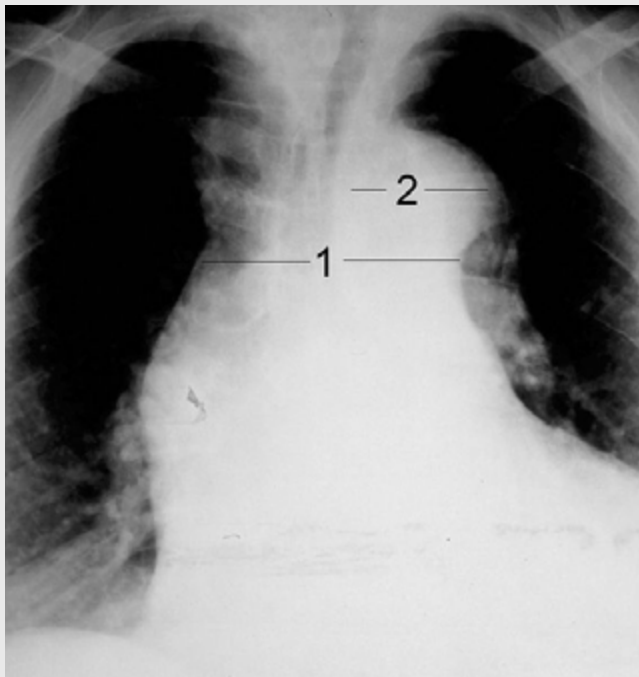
Chest radiograph of aortic dissection type Stanford A.
